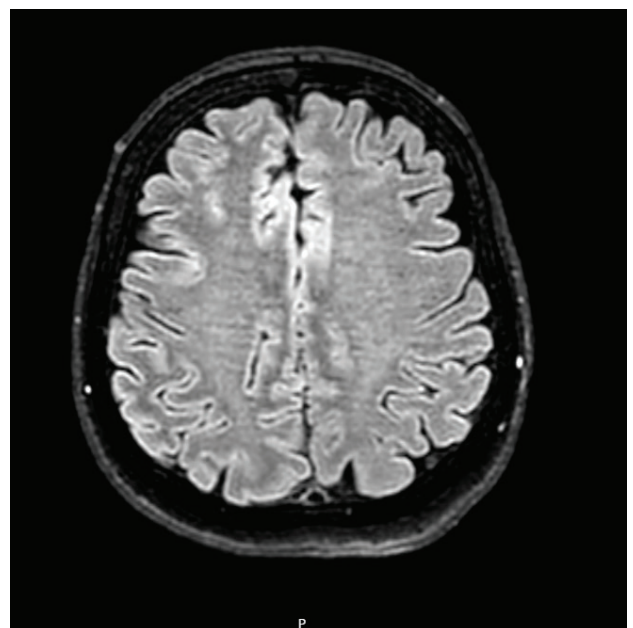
MRI flair sequence.
